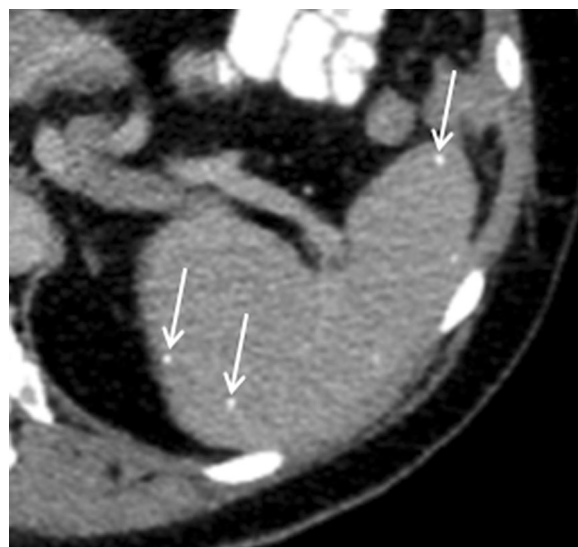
Old granulomatous disease. Axial CT image shows multiple small, high attenuation foci (short arrows) in the splenic parenchyma. This is typical of calcified granulomas.
